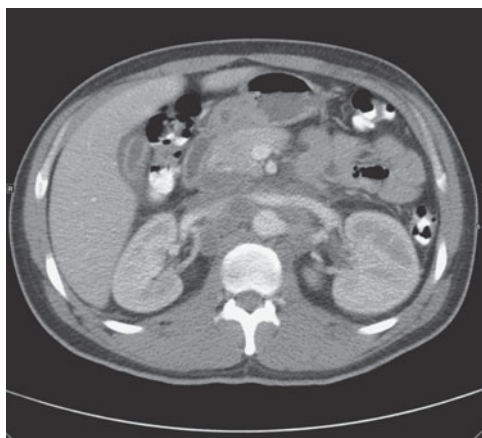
Axial contrast CT scan through the gallbladder showing fluid around the gallbladder.
